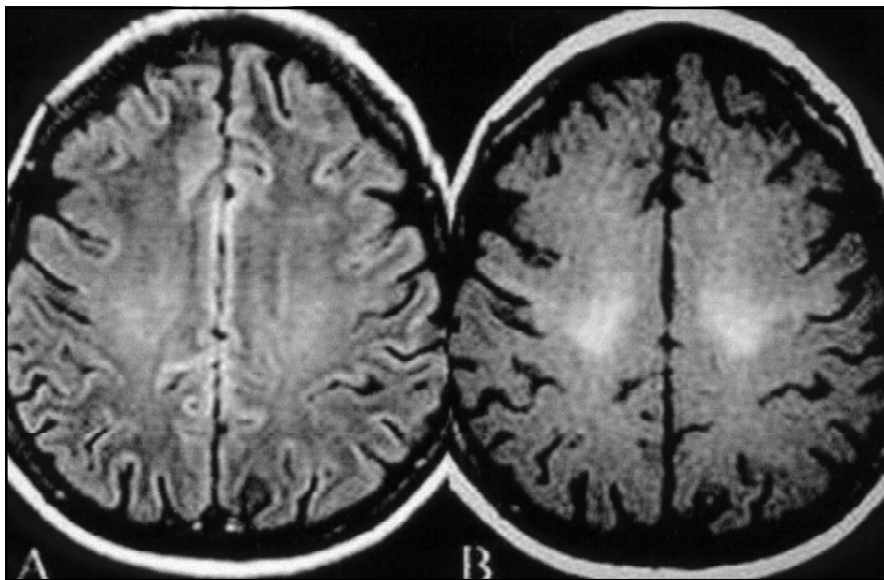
ALS patient. A- Axial FLAIR showing hyperintensity of the pyramidal tracts on the semioval center. B- Axial T1/SE/MT: marked hyperintensity of the pyramidal tracts, more evident than on FLAIR images.
